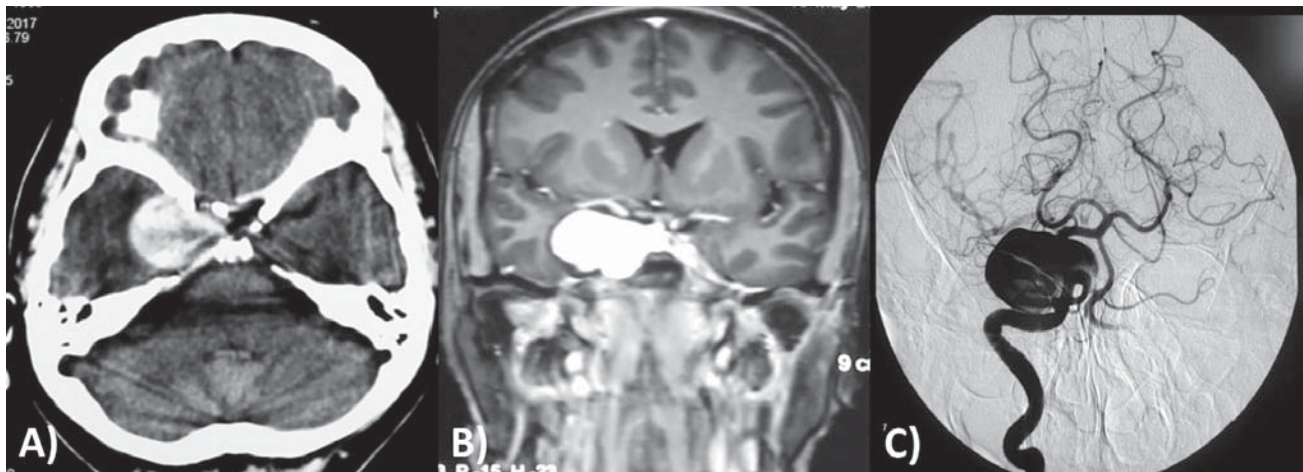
A) CT Head-Contrast shows lobulated enhancing mass lesion at the left parasellar region, B) MRI-Brain shows Large intensely enhancing lesion arising from right cavernous ICA projecting site with extension to right middle cranial fossa suggestive of Giant cavernous ICA aneurysm, C) DSA shows Giant Cavernous Right ICA Aneurysm
